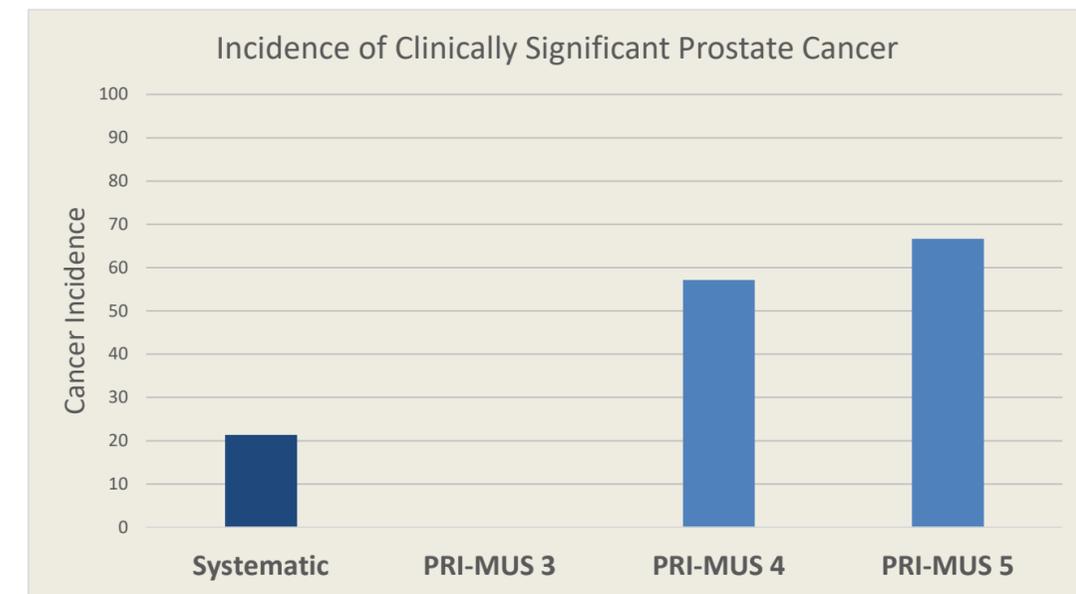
Bar chart with cancer incidence by Micro-US ROI of the target or systematic biopsy. Note that cancer incidence increases with PRI-MUS score. PRI-MUS = Prostate Risk Identification using Micro-Ultrasound, PRI-MUS 1&2 = normal, PRI-MUS 3 = inconclusive, PRI-MUS 4&5 = likely disease. GG=Grade Group (clinically significant cancer = \geq GG2).
